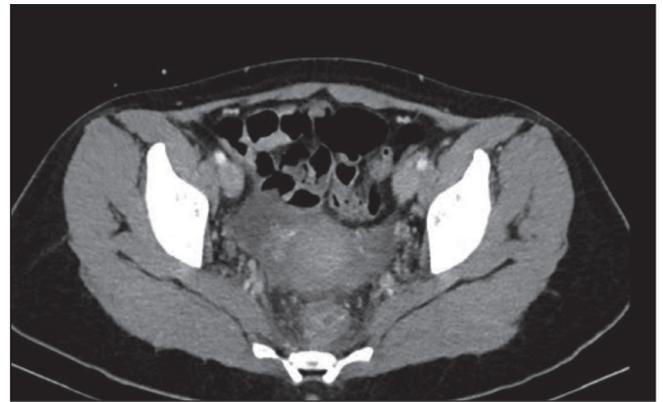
Abdominal CT: congestive-appearing thickening of the walls of the distal sigma and rectum.
